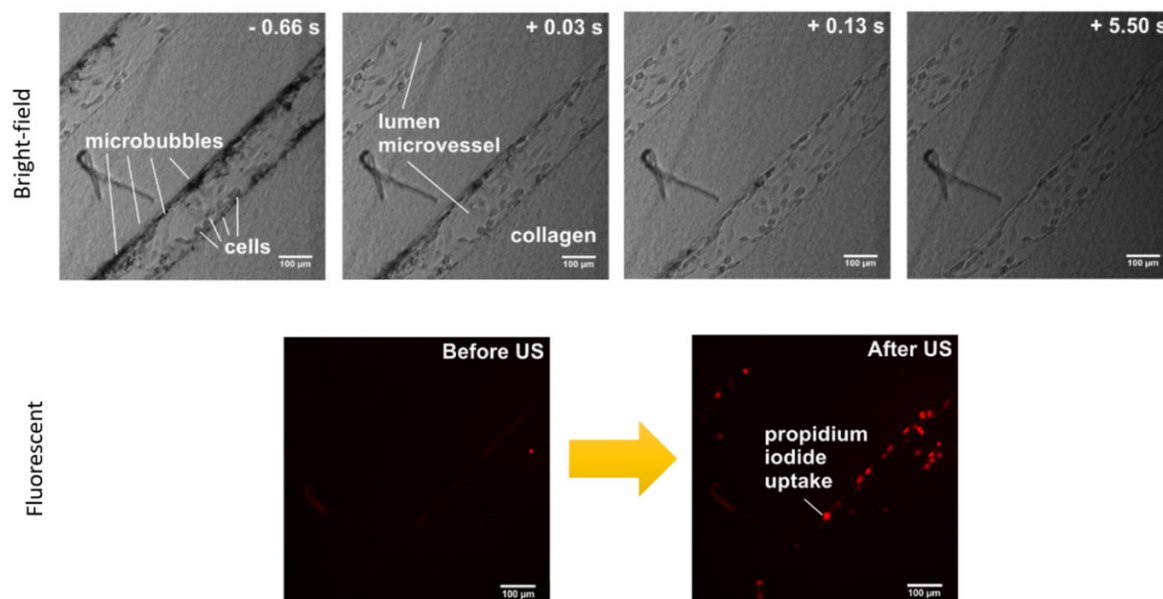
Bright-field (top row) and fluorescent (bottom row) images taken before and after the exposure of an *in vitro* microvessel to the ultrasound. By comparing the bright-field images taken before (-0.66s) and after (+0.03s and onward) ultrasound exposure, we can clearly see that the microbubbles are destroyed by ultrasound. PI uptake significantly increased in regions which microbubbles accumulated before ultrasound exposure.
